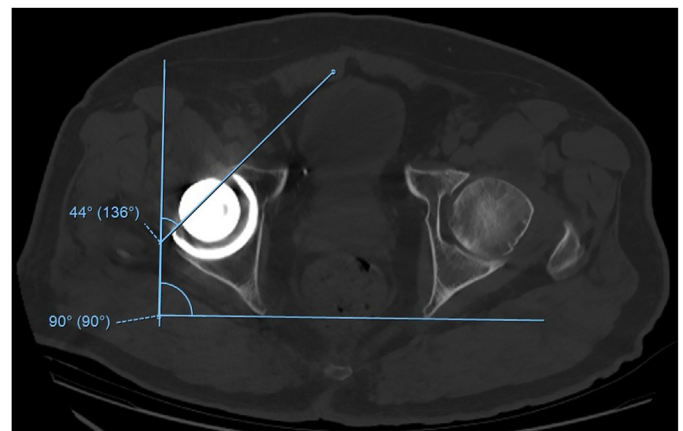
Computed tomography (CT) of the pelvis more than 1 year after THA: Anteversion of the acetabular component is 44 degrees.
